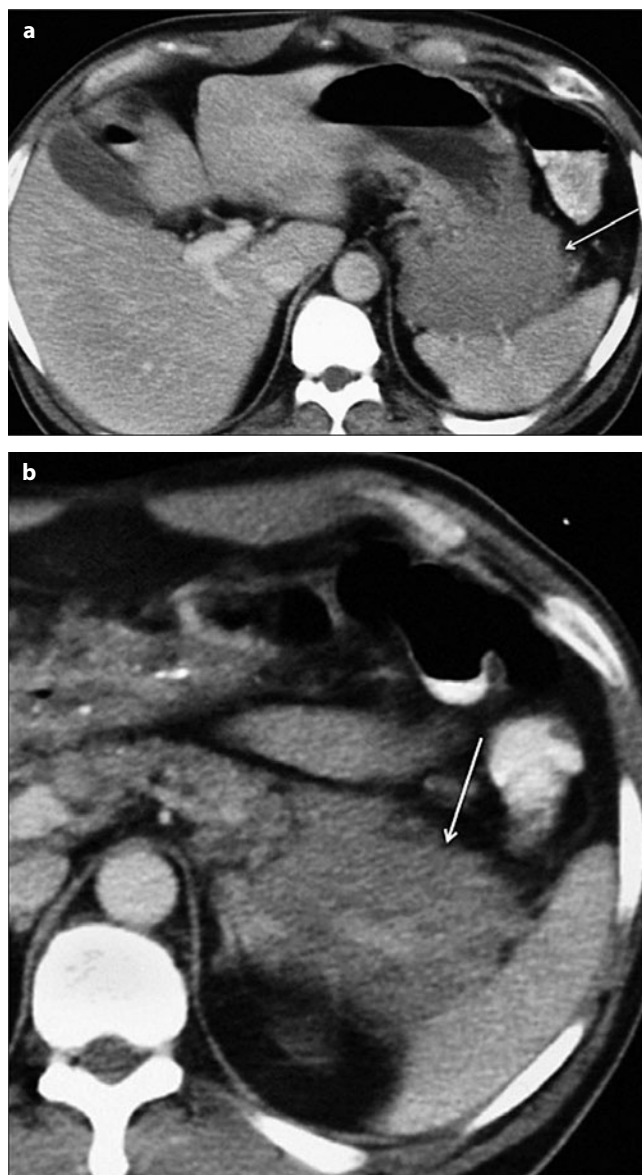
a, b. Transaxial computed tomography (CT) images through a the gastrosplenic ligament (*GSL*) and b the splenorenal ligament (*SRL*) in a patient with lymphoma. Tumor is seen within the *GSL*, interposed between the gastric greater curvature and the spleen (a), and within the *SRL*, encasing the splenic vasculature (b) (arrow)
